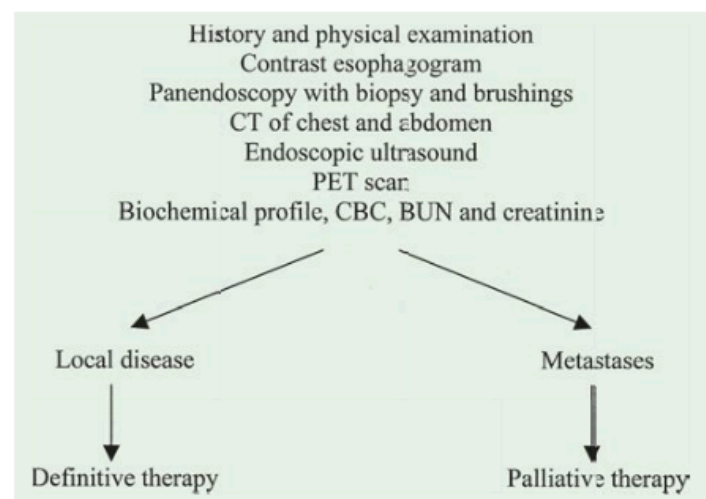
Diagnostic work-up for esophageal cancer. BUN, blood urea nitrogen; CBC, completed blood cell count; CT, computed tomography; PET, positron emission tomography
